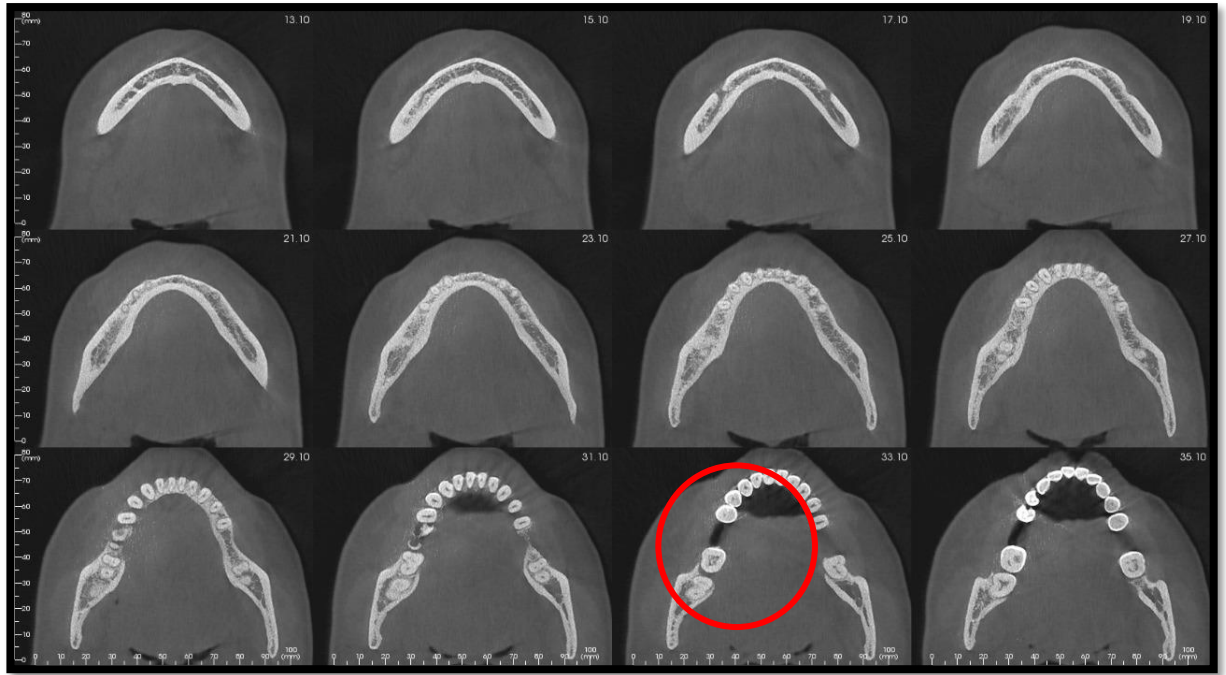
Axial view of pre op CBCT showing implant site with severe bone loss
